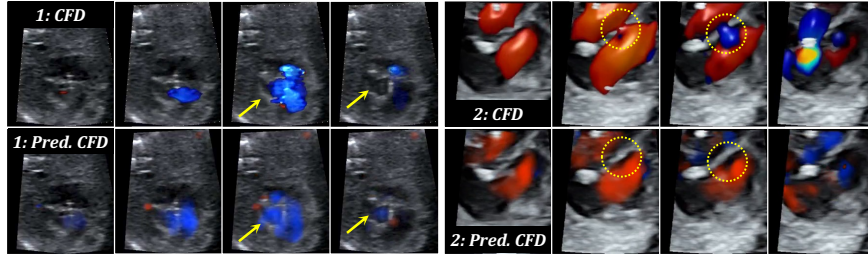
Qualitative case studies demonstrating region-discriminated interpretability. Each case shows a temporal sequence over half cardiac cycle (top to bottom: ground-truth CFD, reconstructed Doppler).
